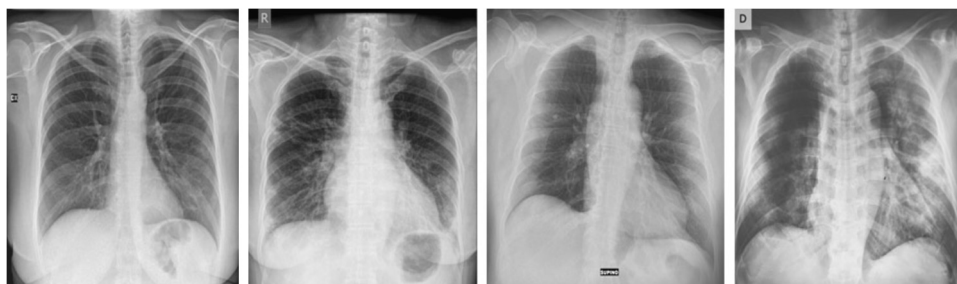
The figure shows Chest X-rays from the dataset indicating typical subpleural peripheral Opacities [9].
